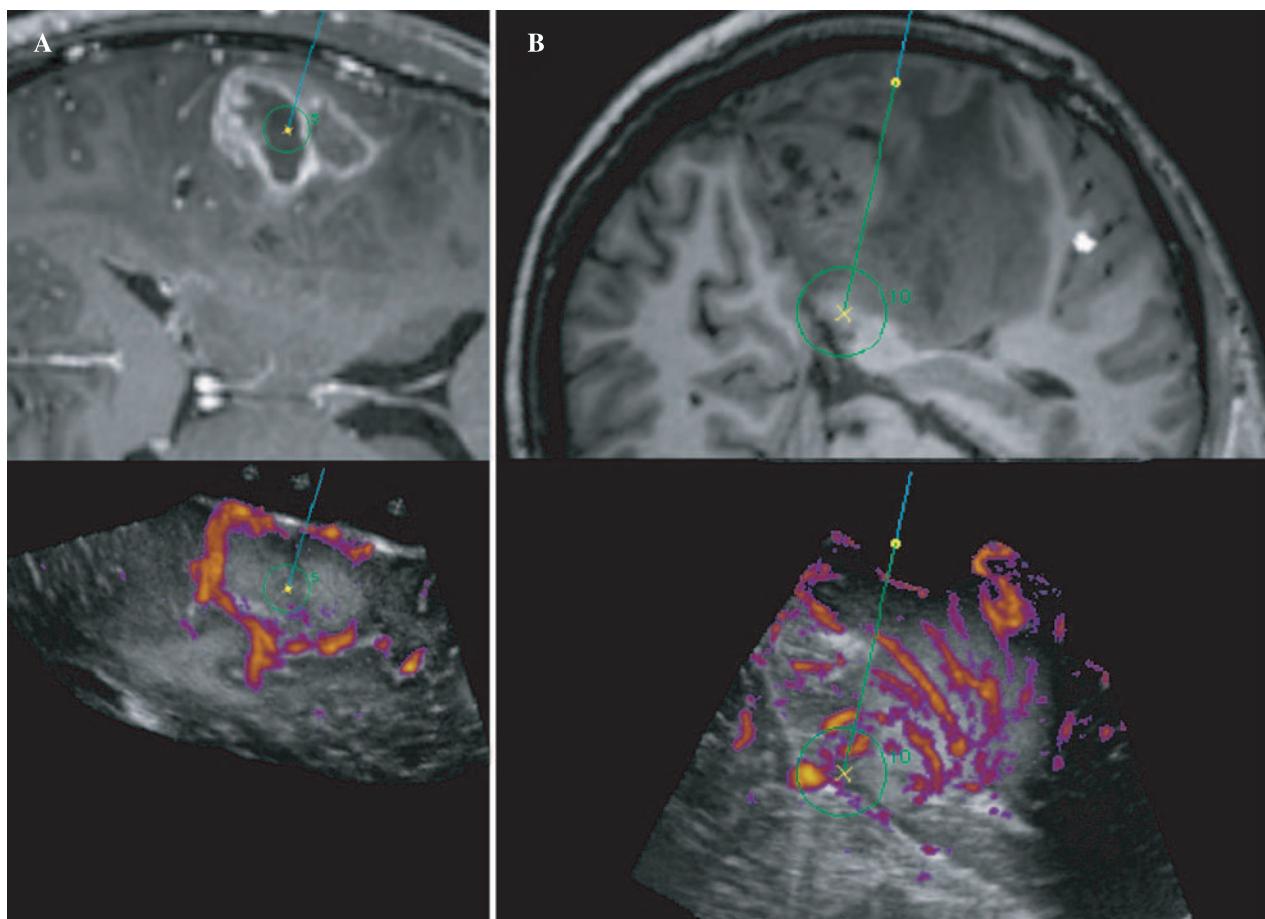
Brain tumors close to vessels (A, patient #1) and infiltrated by vessels (B, patient #10). Intra-operative 3D ultrasound angiography (Power Doppler) was useful for both detecting important vessels near the tumor (bottom row) and for updating pre-operative MR data for brain shift
